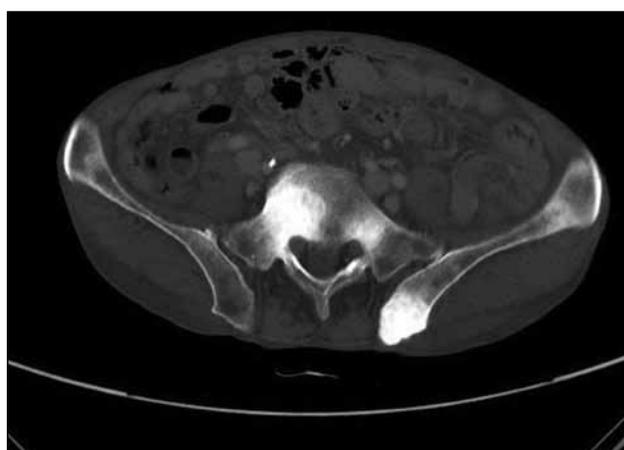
Computed tomography in the bone window setting showing osteoblastic lesions in the sacrum and iliac bones.
